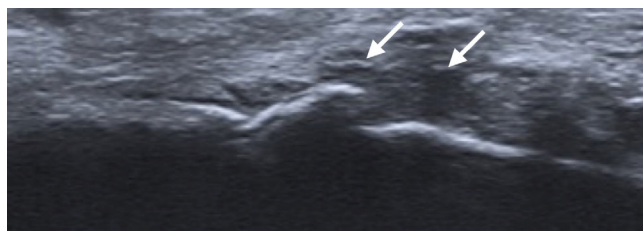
Ultrasound of the right 1st MCP joint, longitudinal view. Effusion and thickening of synovium with embedded small calcifications (a “starry sky” sign), arrows
